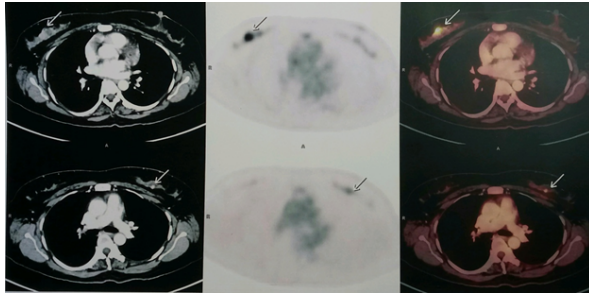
From (L) to (R): CT Thorax, FDG PET Scan showing FDG-avid solid nodular lesions in bilateral breasts in the retro-areolar region and Fusion PET CT images of the same. The lesions are marked by arrows.
